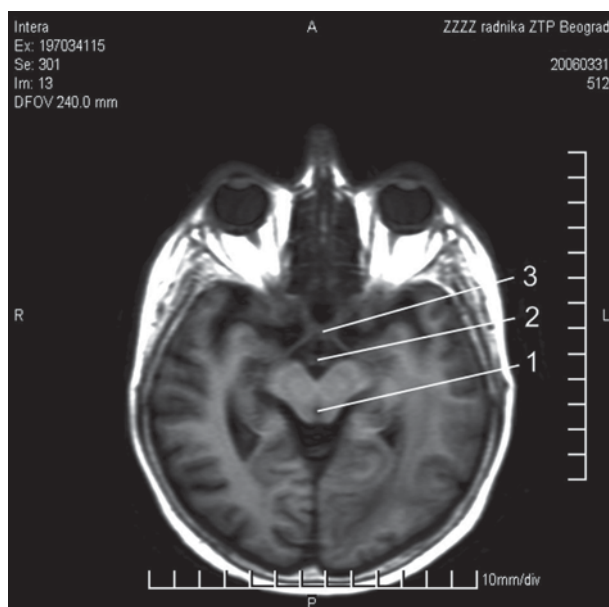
Section of mesencephalon at the level of hiatus tentorii obtained by MRI; 1 – sylvian aqueduct; 2 – basilar artery; 3 – optic chiasm
